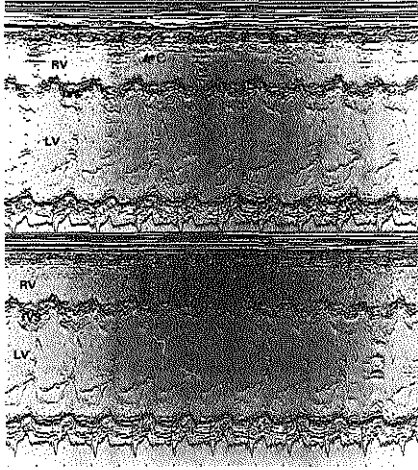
M-mode echocardiograms recorded from a patient who was judged to have definite increase in right ventricular contrast density from the 5% dextrose injection (upper panel) to the following injection of 2 cc of CO_2 in 5 cc of dextrose (lower panel). Injection technique and instrument settings were held constant. C: contrast. LV: left ventricle. IVS: interventricular septum. RV: right ventricle.
